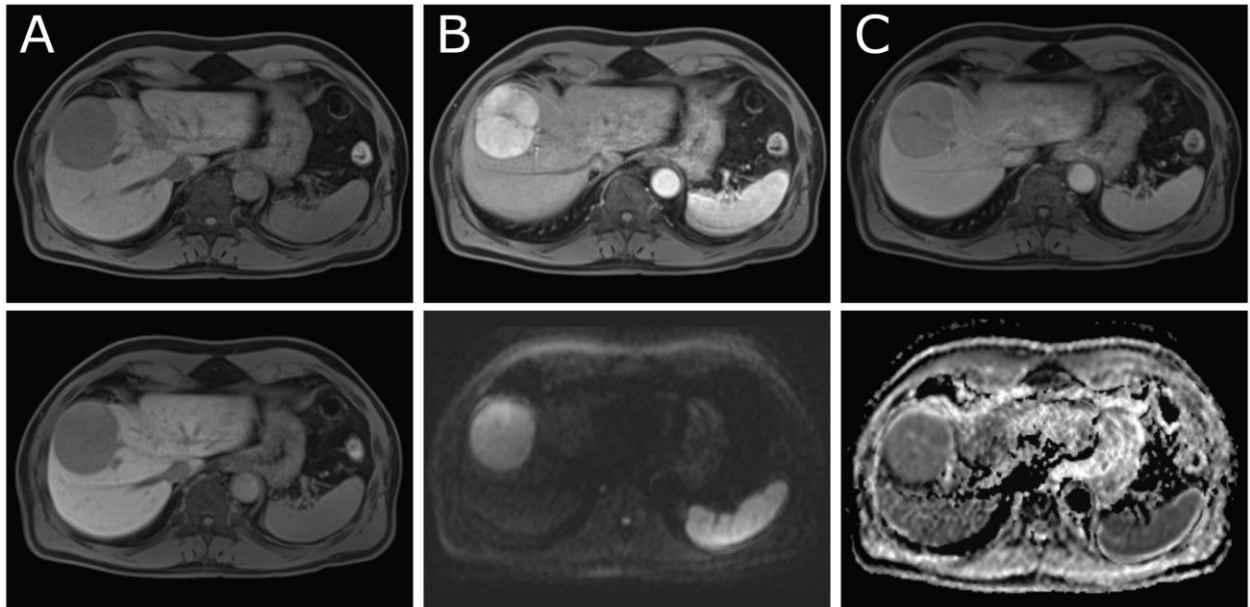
74-year-old man with liver fibrosis and no known risk factors for HCC. Moderately differentiated NOS-HCC in segment VII with a typical enhancement pattern for HCC (A, B) due to marked non-rim APHE from pre-contrast to arterial phase T1w imaging, (C) non-peripheral washout in the portal venous phase and (D) HBP hypointensity. (E, F) Hyperintensity in DWI (B-value 800) and isointensity in the ADC map indicate diffusion restriction, further suggesting HCC.
